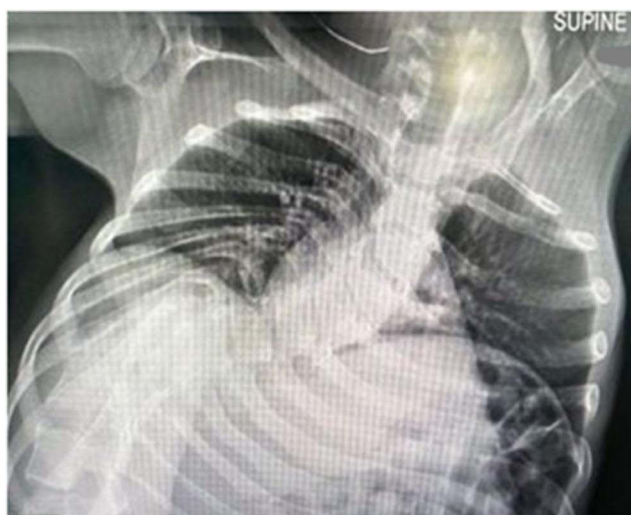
Plain chest radiograph (anteroposterior view) showing a scoliosis of the thoracolumbar vertebra.
